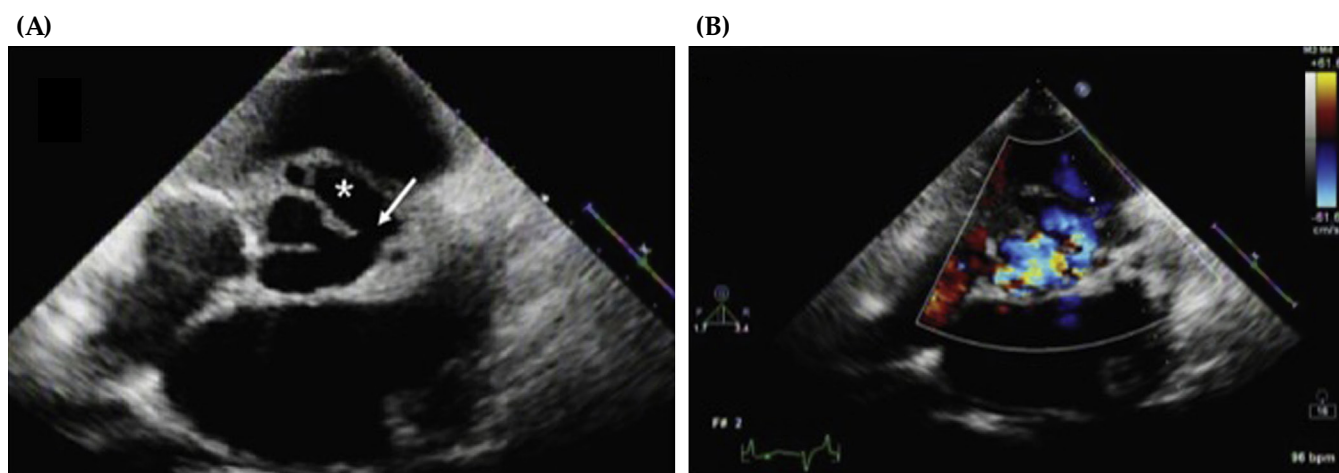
A case of aortic root dissection associated with perforation of the left Valsalva sinus into the left ventricular outflow tract in a 49-year-old woman affected with BD [77]. (A) Parasternal short axis view at the aortic level shows the echolucent cavity (*) between the aortic root and the left and right Valsalva sinus, and a perforation (arrow) of the left Valsalva sinus. (B) Short-axis view of the aortic root with color-flow imaging demonstrating blood flow streaming through the perforation of the left Valsalva sinus into the dissection between the aortic root and the Valsalva sinus. Adapted from Zhao et al. [77].
